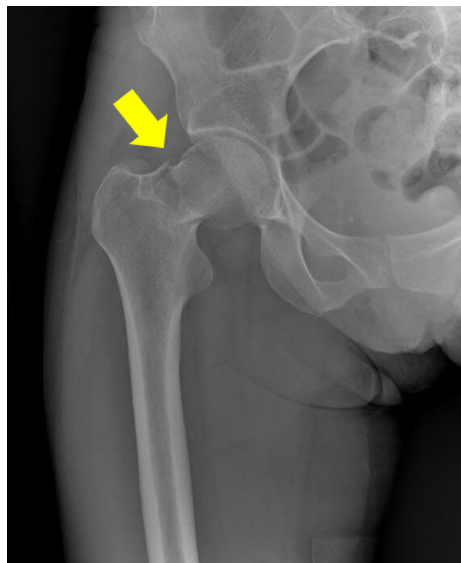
Right hip radiography with femoral neck fracture (arrow)
